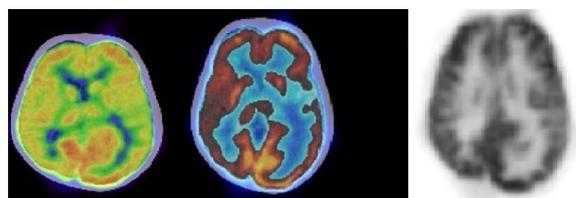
¹⁸F-FDG PET/CT axial sections of brain show that left cerebrum appears bulky as compared to contralateral side. Distinction of the gyri and sulci are lost in the left cerebrum. Chinking of anterior, lateral and posterior horn of left lateral ventricle is seen and midline shift towards right is noted. The MIP images in axial section show hypometabolism is seen in the middle and superior temporal gyrus on left side and in areas adjacent to left central gyrus (SUV max=4.2 with respect to SUV max=5.4 on contralateral side).
